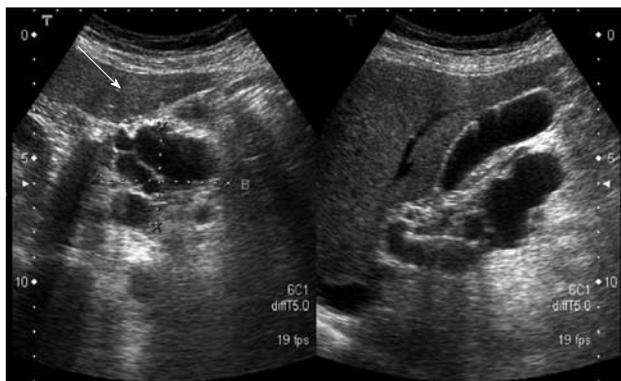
Abdominal ultrasonography showing multiple cystic tumors over the pancreatic head area with P-duct dilatation.
